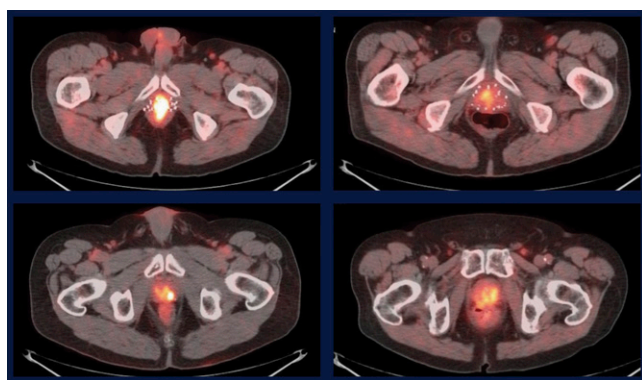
Representative anti-3- ^{18}F -FACBC PET/CT images in patients with similar prostate-specific antigen (PSA) levels but different SUV_{max} at 17 minutes. Top row: patients with low PSAs of 2.2 (left, with an SUV_{max} of 6.5 and early failure) and 1.6 (right, with an SUV_{max} of 2.2 and no early failure). Bottom row: patients with high PSAs of 9.3 (left, with an SUV_{max} of 10.9 and early failure) and 10.4 (right, with an SUV_{max} of 4.4 and no early failure).
